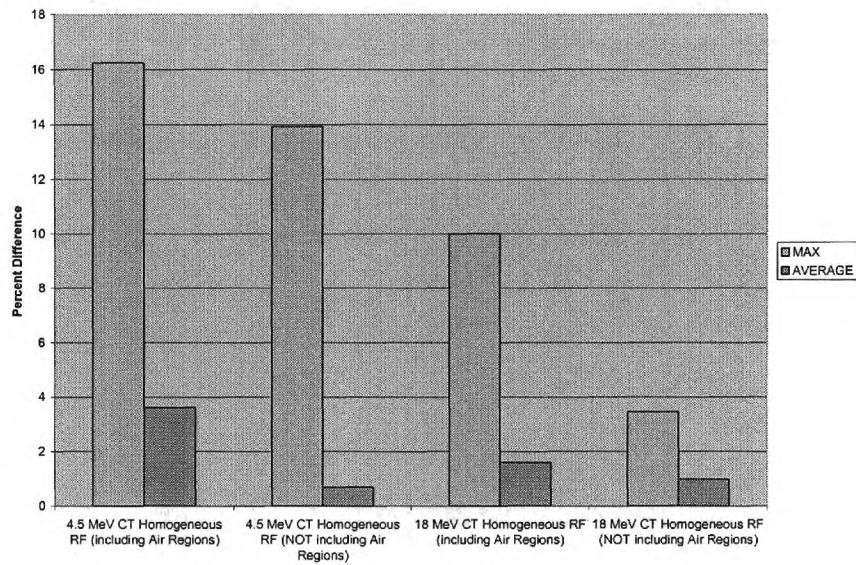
Percent Difference for CT Benchmark
